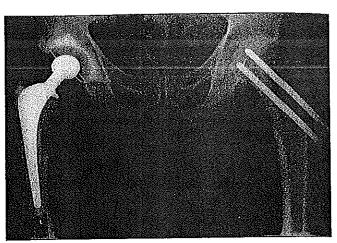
Radiograph of a patient demonstrating a healed femoral neck fracture on the patient's left side after hook-pin osteosynthesis and a cemented total hip arthroplasty without signs of loosening on the patient's right side.
